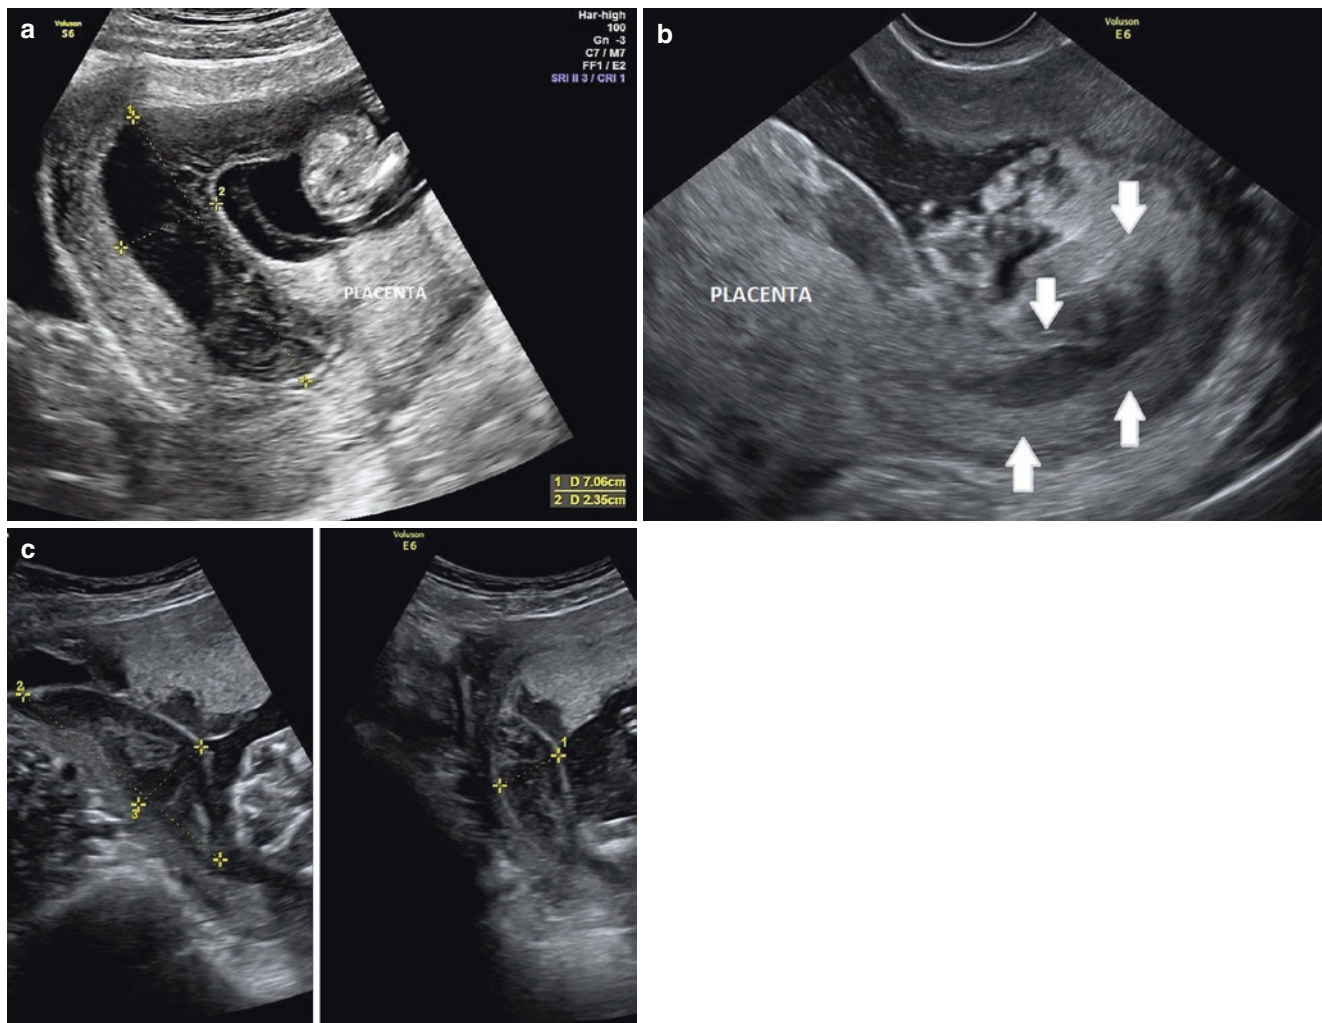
Transabdominal sonogram of marginal sonolucent hematoma (a–c)
